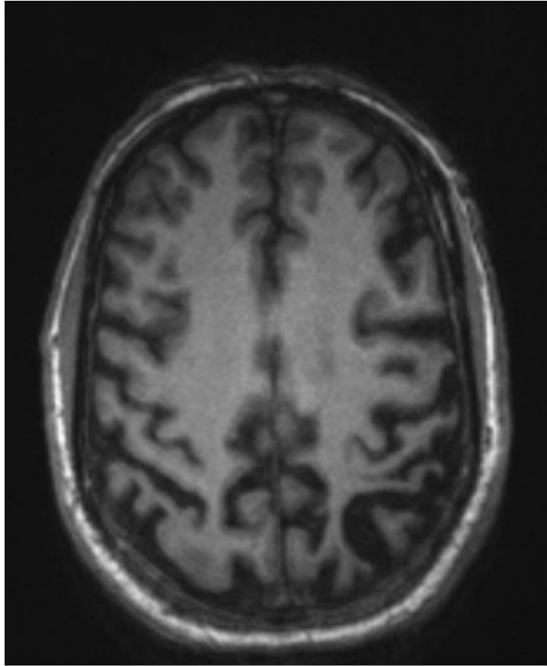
Axial MRI of Case 6 showing severe left-lateralized peri-Rolandic and parietal cortical atrophy, consistent with the pattern of atrophy typically seen in the CBS syndrome.
